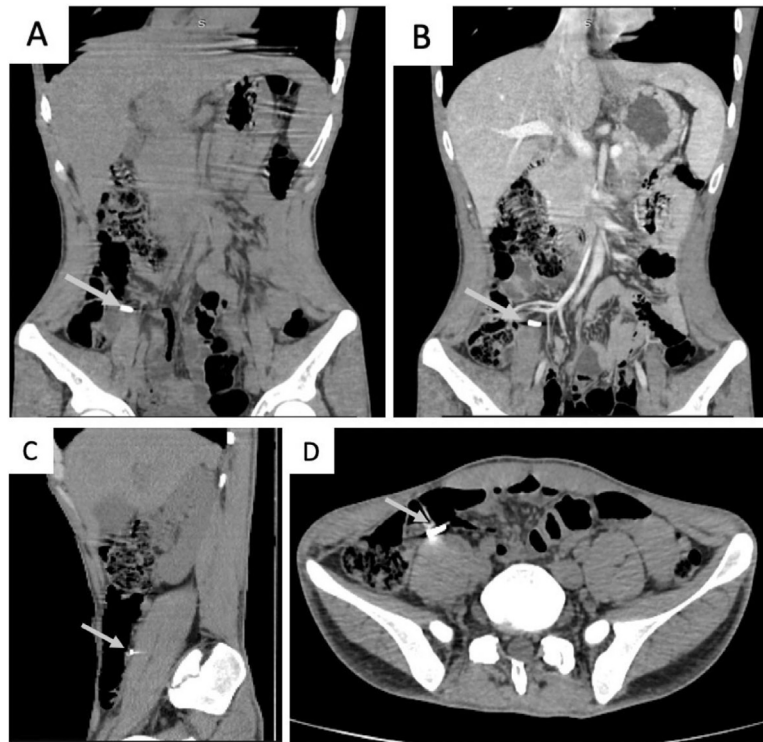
Abdominal CT scan without contrast injection (A, C and D) and with contrast injection (B) showing the clip disposition in coronal plane (A, B), sagittal plane (C), and in axial plane (D).
